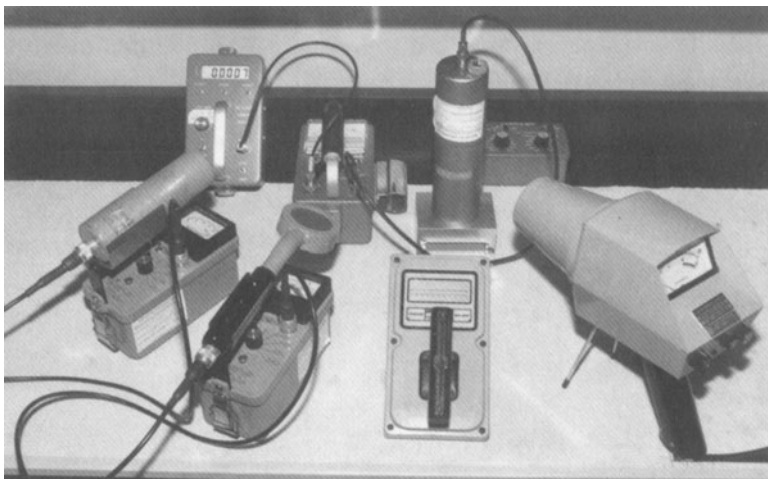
Monitoring and surveying instruments. These are used to detect spills and stray radiation. Front row, from left: ratemeter with low-energy gamma probe; ratemeter with pancake probe for beta detection; survey meter for gamma and high-energy beta; area-survey meter for detecting gamma and x-ray radiation fields. Back row: alpha detection probe; ratemeter with scalar.
